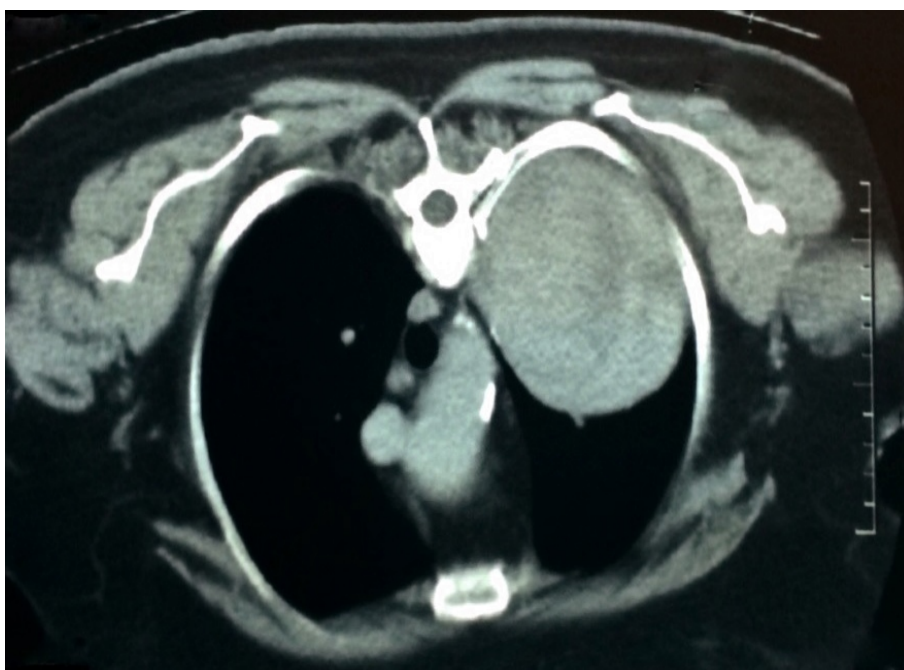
CT-scan disclosing left lung lower lobe mass
